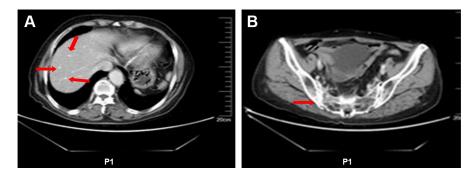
MRI findings after 4 cycles of CIK cells plus chemotherapy.
